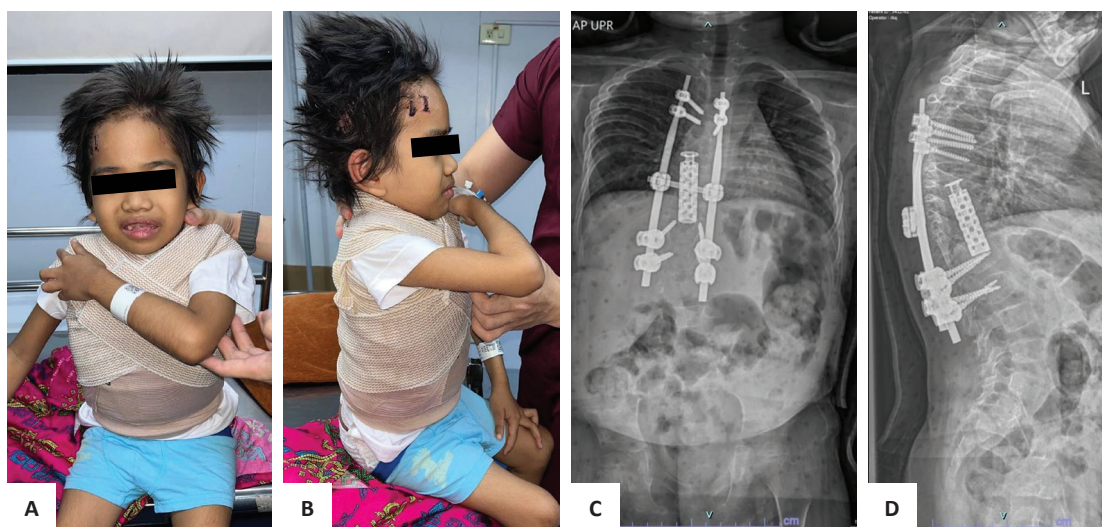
Patient one day after removal of halo-pelvic traction (A, B). X-rays one day after removal of halo-pelvic traction (C, D).
